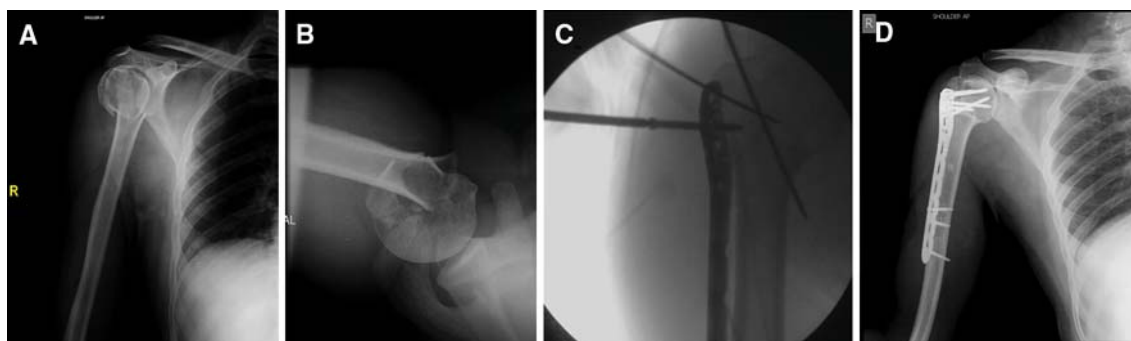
a, b Preoperative radiographs of a three part fracture, c intraoperative fluoroscopy image showing closed reduction and provisional fixation with K wires, d final reduction and fixation
